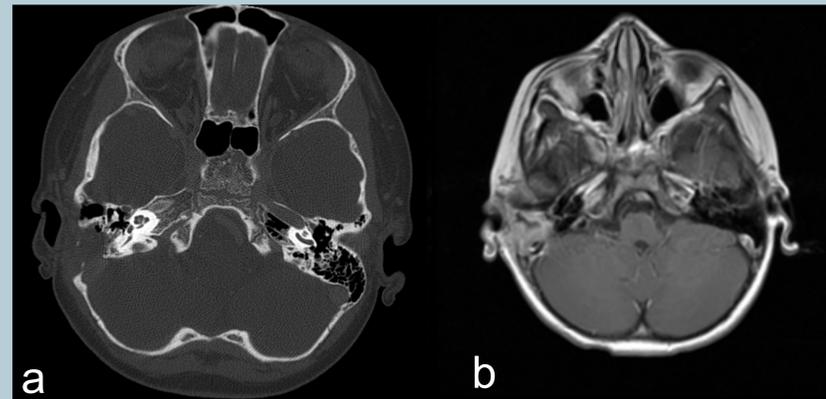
Unifocal LCH of the Right Temporal Bone. a) axial CT w/o contrast, osteolytic lesion of the right mastoid with erosion into the posterior fossa, b) axial MRI T1 with contrast, soft tissue lesion of right mastoid and intracranial extension into posterior fossa
